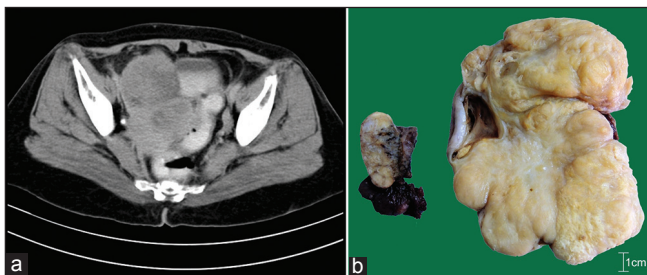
(a) Computed tomography showing 9.5 cm × 6.9 cm × 6.8 cm sized well defined, heterogeneous, partly solid and partly cystic lesion in pelvis superior to urinary bladder. Fat planes with bowel loops and uterus were lost. Both ovaries were not seen separate from the lesion. (b) The cut surface of the left ovary measuring 3.2 cm × 1.5 cm × 1 cm showing whitish and yellowish areas, The cut surface of the right ovarian mass measuring 10.5 cm × 7.5 cm × 4.5 cm showing predominantly solid with few cystic brownish areas. Solid areas showed yellowish with few whitish areas. Cysts varied in size from 0.5 to 2 cm
